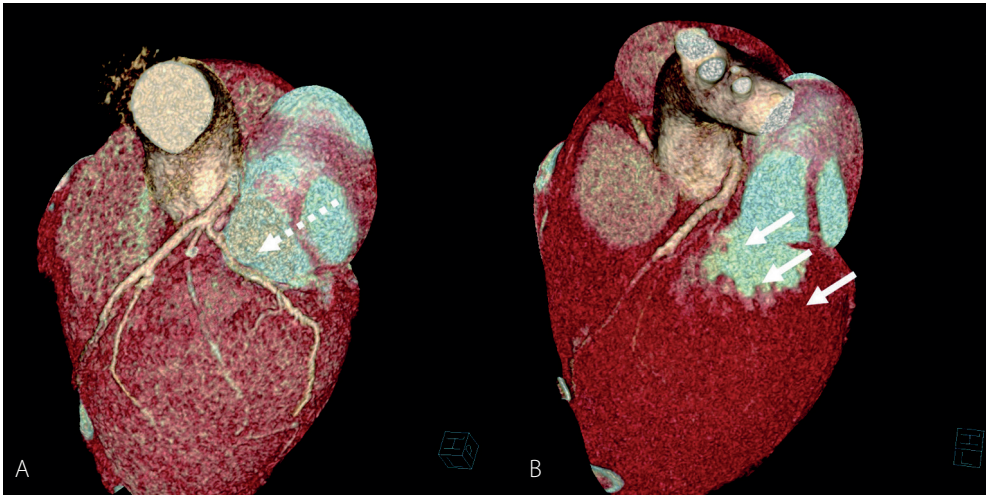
Pre- and postoperative contrast enhanced cardiac CT in a patient with postoperative iatrogenic occlusion of the RCx after mitral valve repair.
